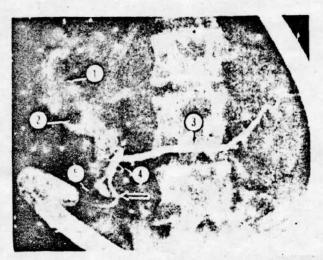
X-Ray shows cannula entering papilla (arrow) E.R.C.P. delineates common bile duct (1) with stone (2) Pancreatic tree (3), Knee (4), duct of Santorini (5), which usually opens higher up in duodenum through an accessory papilla.
